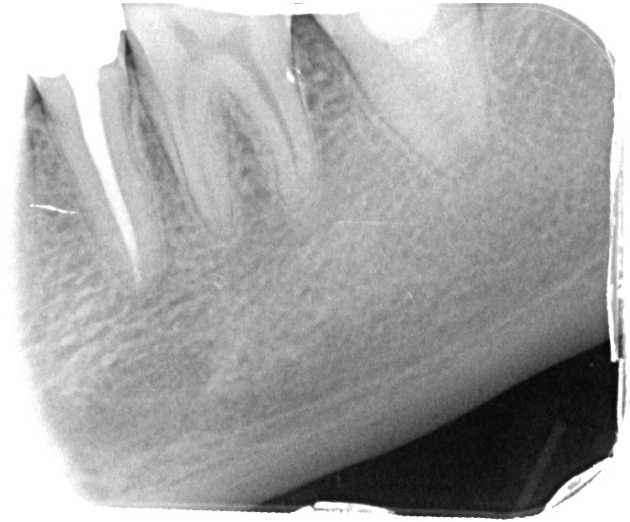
12-month follow-up radiograph
